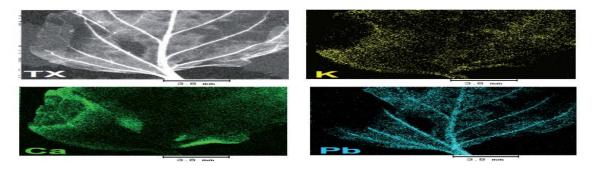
Analysis of leaf after introduction of pollutant to root system. Transmitted x-ray (TX), potassium (K), calcium (Ca) and lead (Pb) mapped images are shown.
